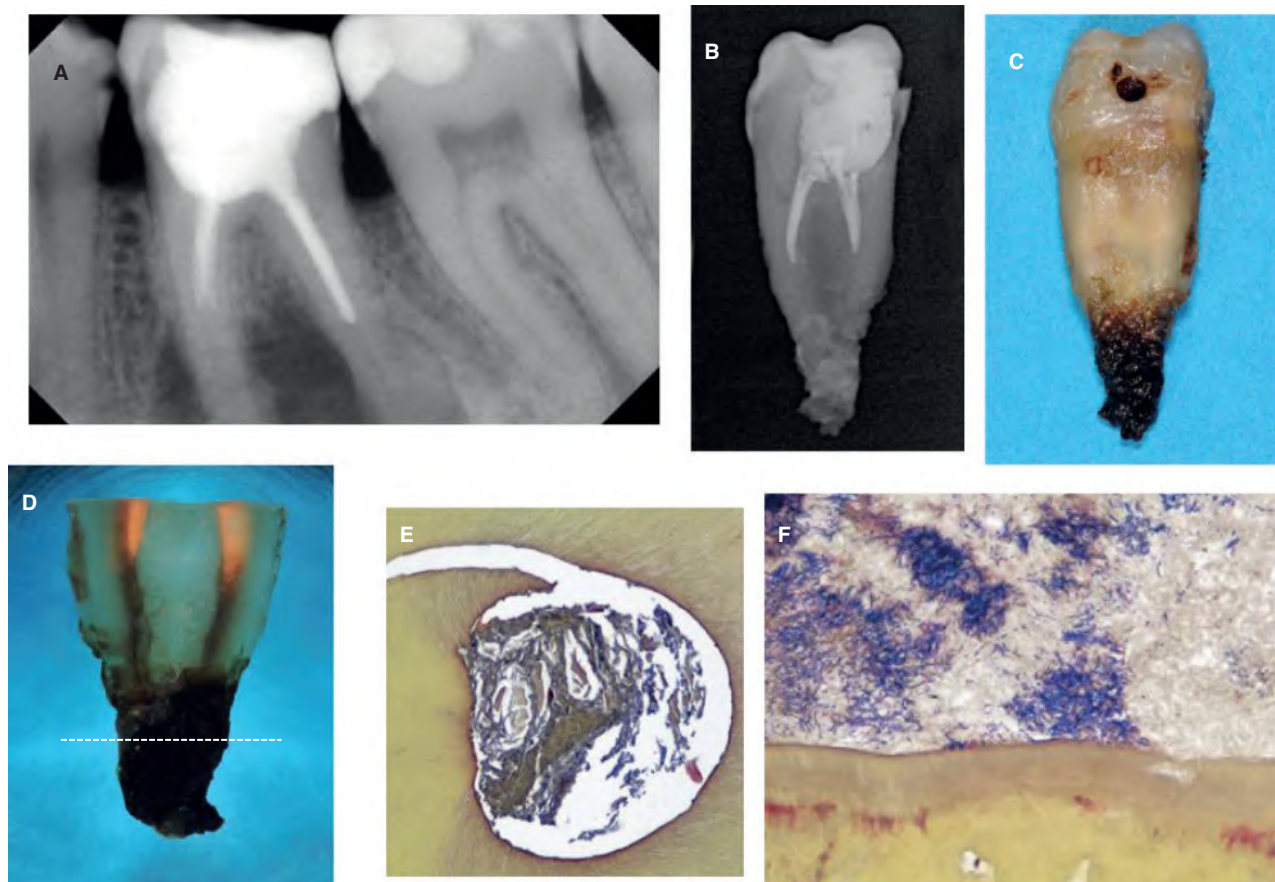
Symptomatic root canal-treated mandibular first molar with a large periradicular radiolucency. A. The apices cannot be seen on the radiograph, but an unusual indistinct radiopacity is appreciated around the mesial root, as well as a net radiopacity around the distal root tip. B. Radiograph of the mesial root in a mesio-distal projection. C. Photograph of the mesial root. The root tip is completely covered by dark calculus and considerably resorbed. D. Apical half of the mesial root immersed in the clearing agent before paraffin infiltration. E. Cross-cut section at the level of the line in D. The buccal canal is completely filled with necrotic debris and dentin chips enmeshed with microorganisms (Taylor's modified Brown and Brenn, original magnification $\times 100$). F. Same section. Distal aspect. Microbial biofilm with abundant extracellular matrix adhering to cementum ($\times 400$).
